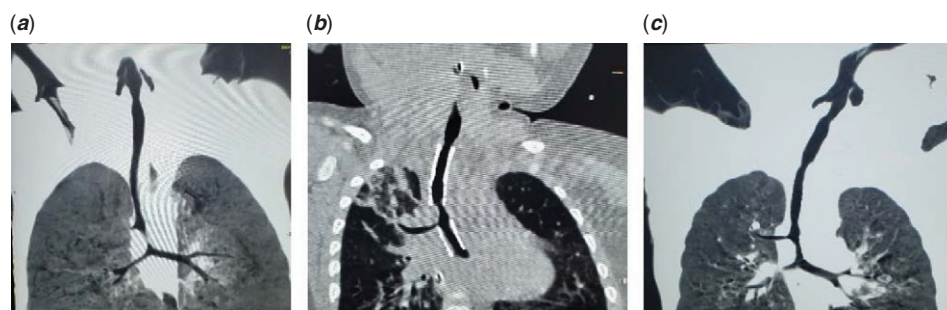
Chest CT. (a) before operation; (b) tracheal stents; (c) 6 months after flexible fiberoptic bronchoscopy.
